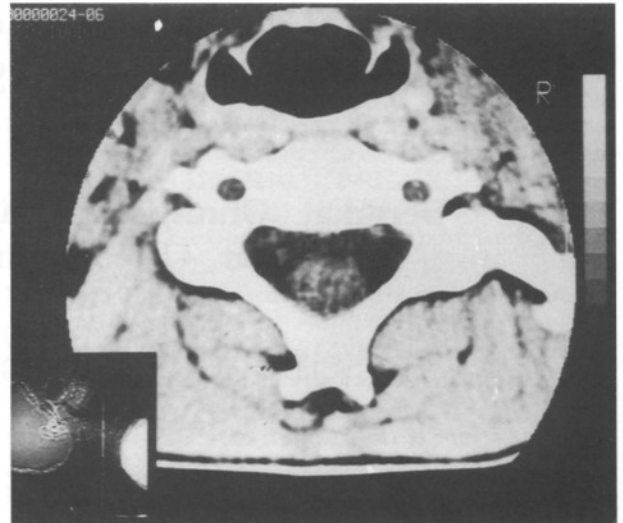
An axial CT scan shows a calcified lesion arising from the right transverse process of the C5 vertebra.
